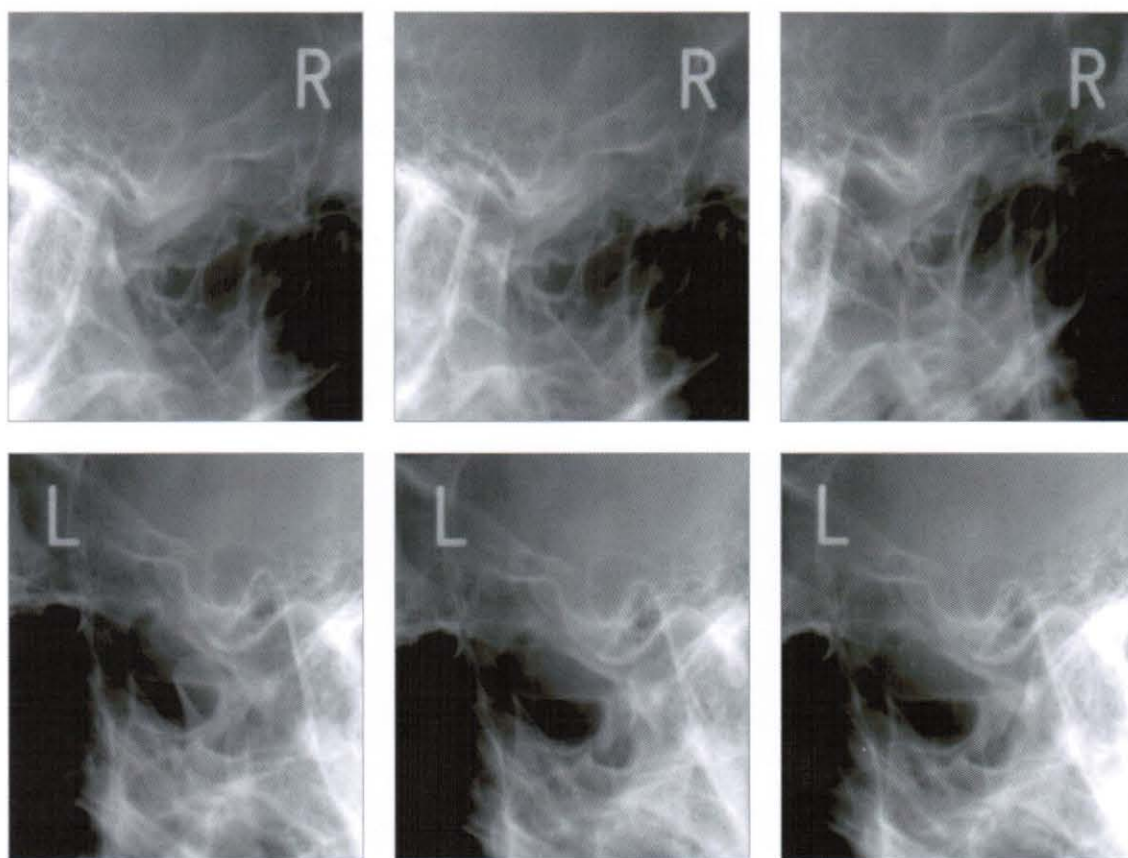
Presurgical transcranial radiograph
